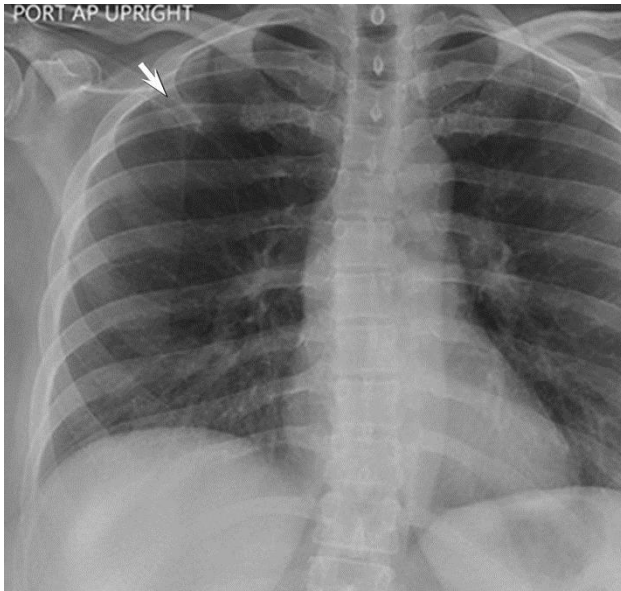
Initial frontal chest radiograph (same as Figure 1) but with an arrow showing a poorly defined nodular opacity in the right apex.
